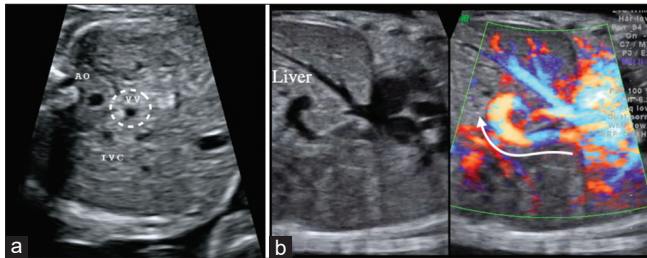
Prenatal ultrasound findings at 28 weeks of gestation in a case of infracardiac total anomalous pulmonary venous return. (a) Besides the left posterior descending aorta and right anterior inferior vena cava, an additional vertical vein (dashed line circle) can be found in the abdominal plane, (b) sagittal view of the vertical vein: The vessel goes downward through the diaphragm and drains into the liver (arrow). Ao: Aorta, IVC: Inferior vena cava, VV: Vertical vein
